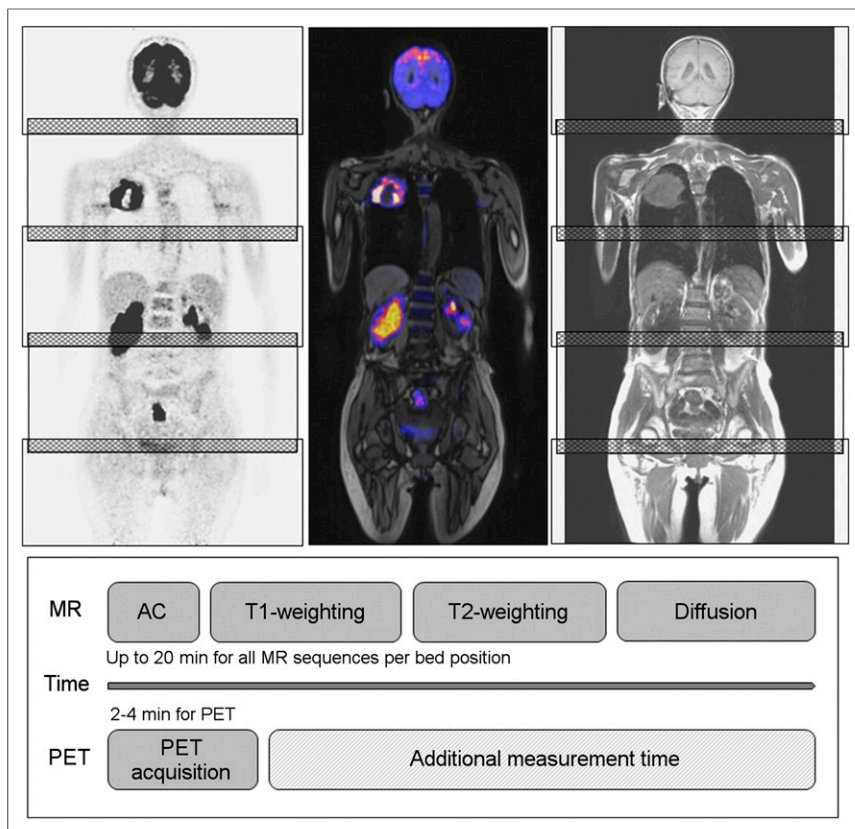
Simultaneous PET/MR whole-body data acquisition. PET (left) and MR (right) data acquisitions are performed simultaneously during multistep examination with typically 5 bed positions for whole-body coverage; cross-hatched sections represent overlapping field of view. Standard MR data acquisition encompasses localizer, sequences for AC, and, for example, T1- and T2-weighted imaging for anatomic reference. Further sequences may be added to MR protocol. Simultaneous PET data acquisition requires only 2–4 min per bed position. Relatively longer MR data acquisition times thus provide potential for increased PET data acquisition times.
